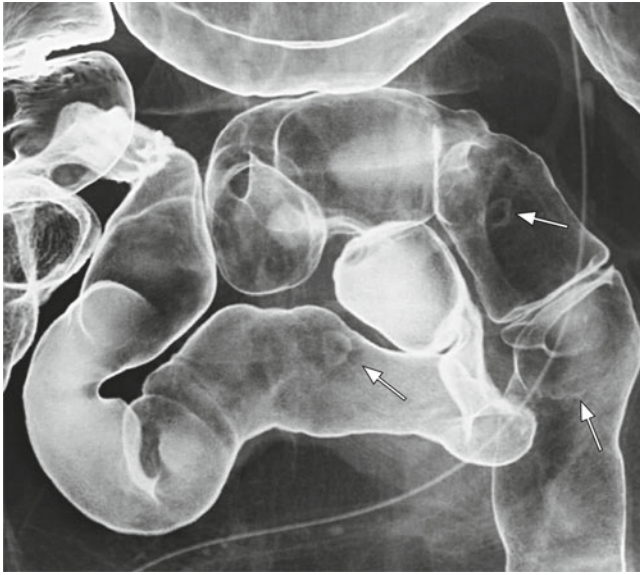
Radiography revealed sharply demarcated barium flecks with filling defects at the borders in the terminal ileum (*arrows*)
